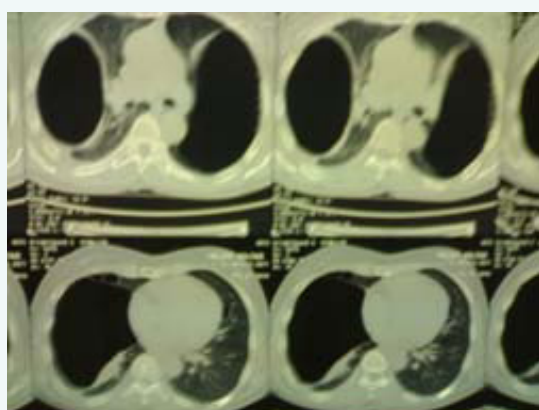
Show CT Scan with bilateral bullae.
